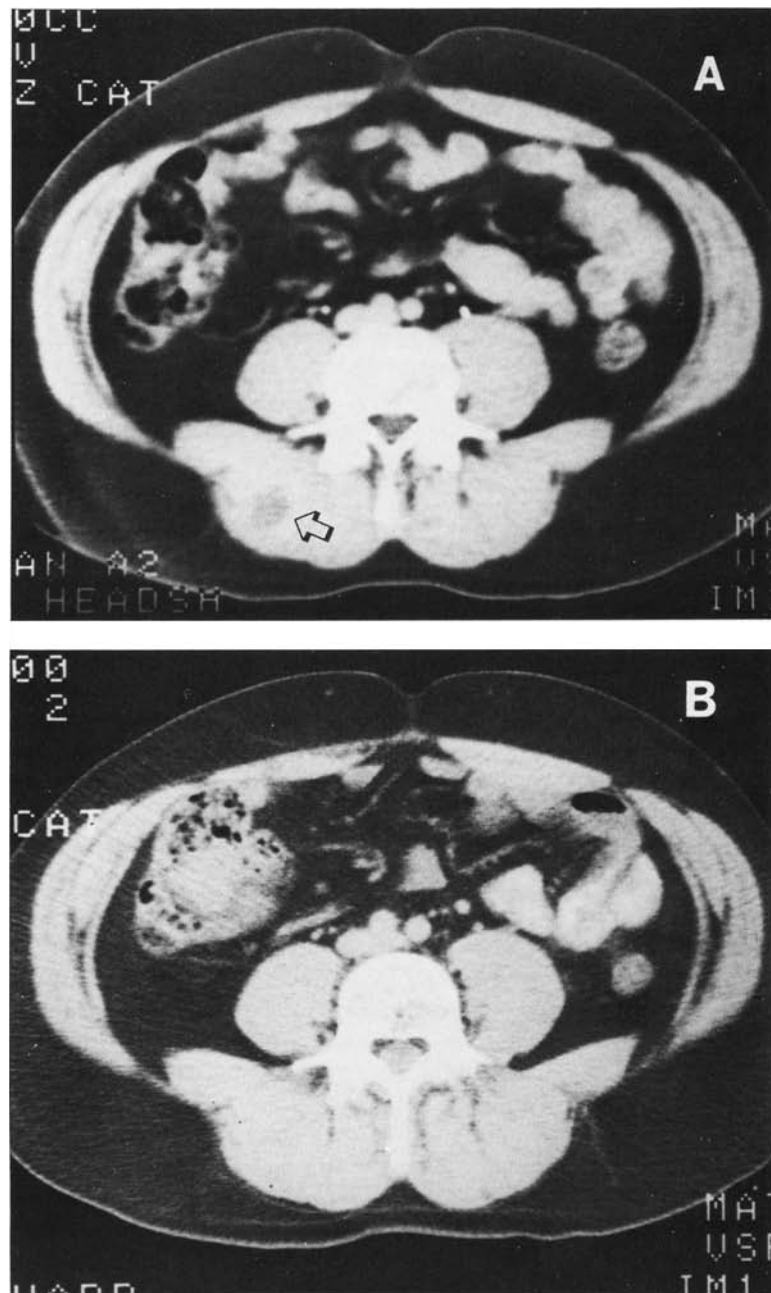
Abdominal CT scans of patient no. 6 show metastatic melanoma in the rectus spinalis muscle (arrow). (A) Before 3F8 treatment. (B) After 3F8 treatment.
